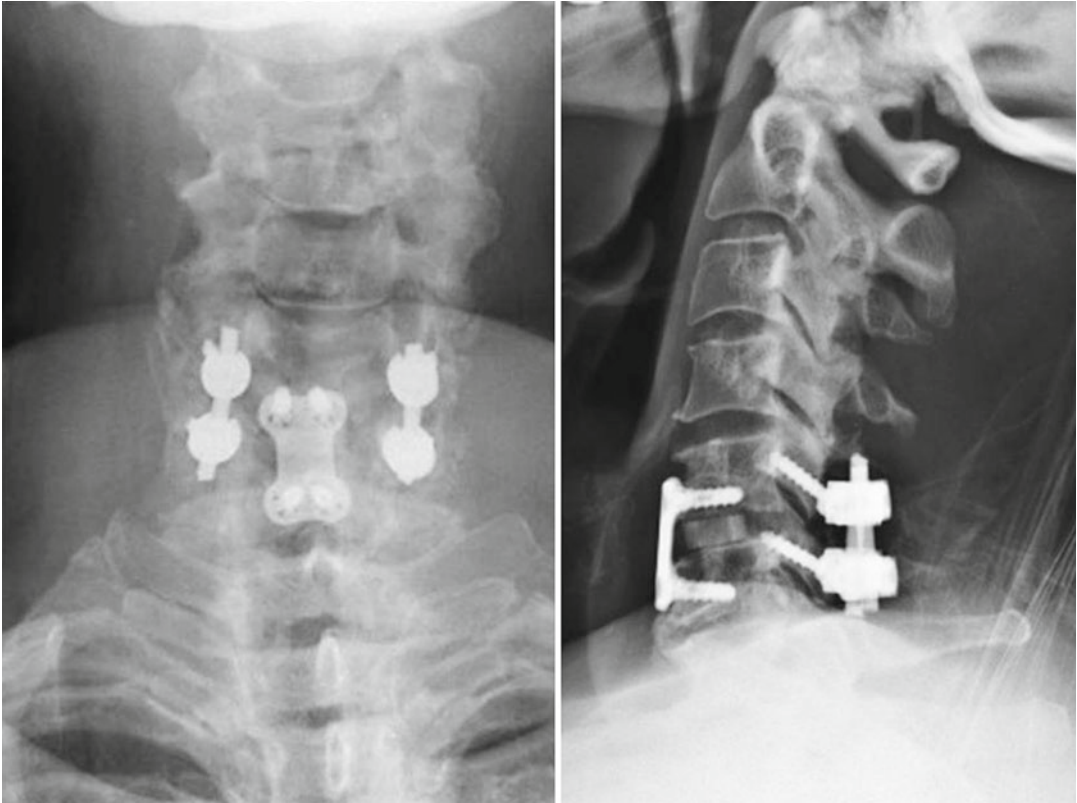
Postoperative anteroposterior and lateral X-rays depicting C5–6 anterior cervical discectomy and instrumented fusion with insertion of machined, lordotic, allograft, interbody spacer coupled with instrumented posterior C5–6 fusion and decompression which includes
